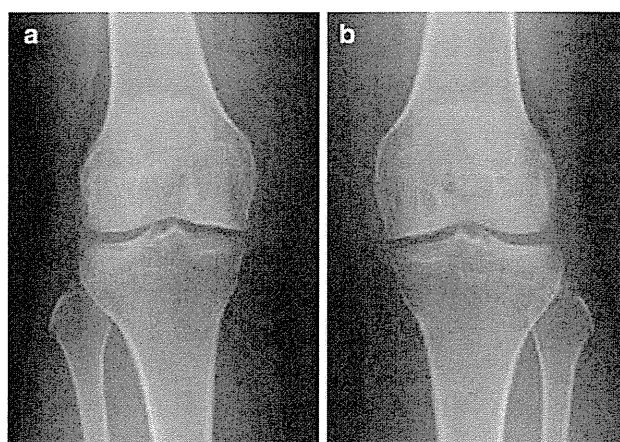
Radiographs showed no apparent progression of osteoarthritis in the bilateral knee. The medial joint spaces were preserved. a Anteroposterior radiograph 8 years after surgery of the right knee. b Anteroposterior radiograph 10 years after surgery of the left knee
